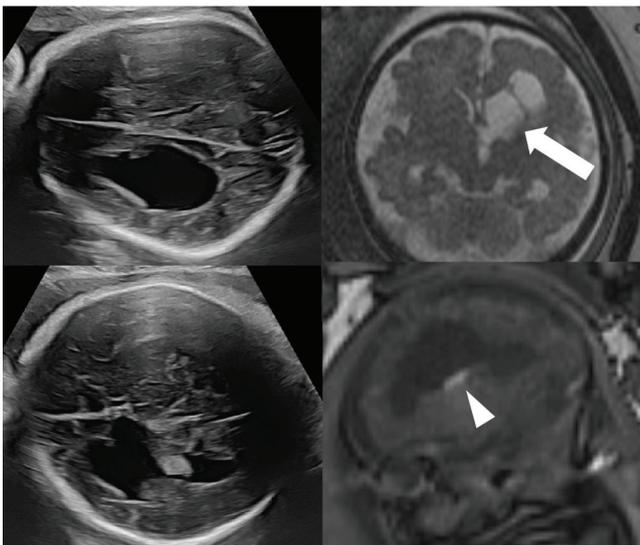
Image demonstrating progressive ventriculomegaly. Ultrasound image (left) showing left ventriculomegaly with a hyper-echogenic blood clot in the lateral ventricle. Magnetic resonance imaging (right) showing the same results, indicating ventriculomegaly (arrow) and a hyper-echogenic blood clot (arrowhead).
